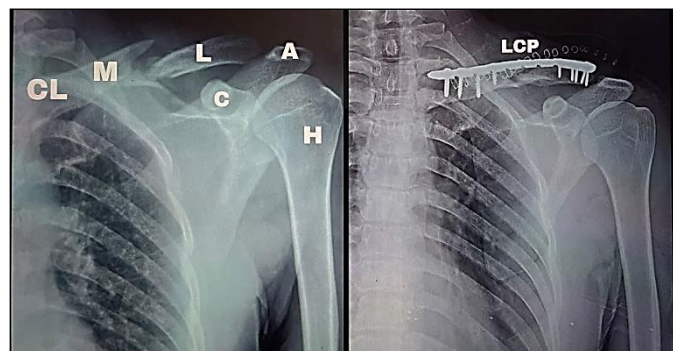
Pre-op and immediate post op x-rays following ORIF with pre-counteracted locking plate and screws. CL-Clavicle, L-Lateral fracture segment, M- medial fracture segment, C-Coracoid process, A-Acromion, LCP-pre-counteracted lateral locking compression plate, H- Humerus, A-Acromion
